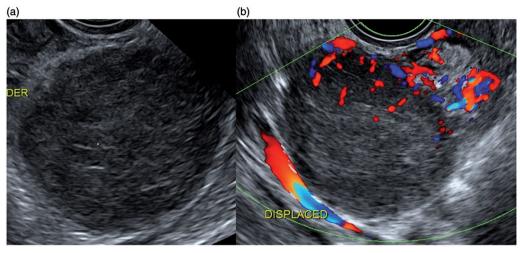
Ultrasonographic appearance of a para-ovarian adrenal rest tumor demonstrating an echogenic border (a), increased blood flow, and compression of the external iliac vein (b).
